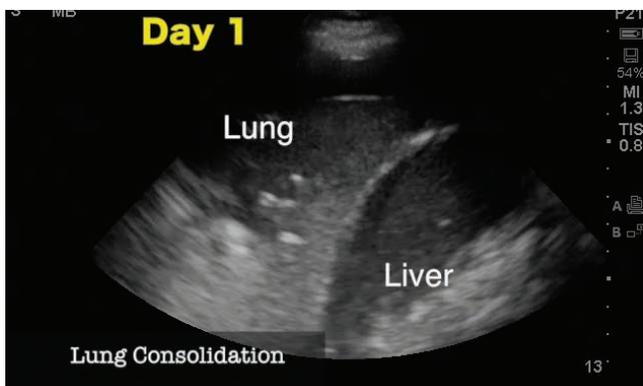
Transthoracic image depicting the consolidation “tissue sign” of the right lower lobe of the lung.
